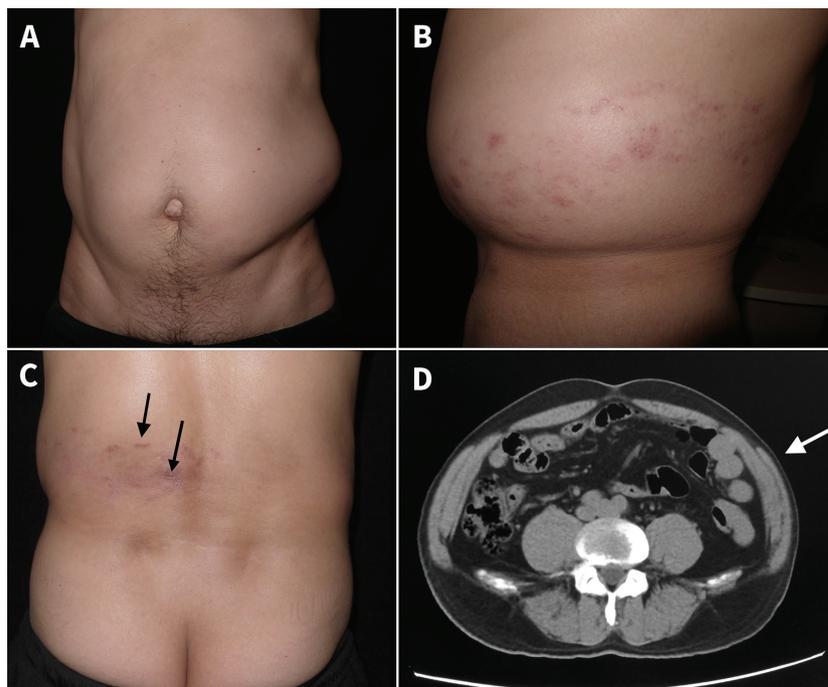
(A)–(C) A reducible protrusion in the left flank with several red to light brown macules and scars on the overlying skin in a 57-year-old man with a six-week history of herpes zoster in the left T11–T12 dermatomes. (D) Computed tomography at L3 showed no abnormality in the left lower abdominal wall in the region of the pseudohernia (arrow) compared with the right.
